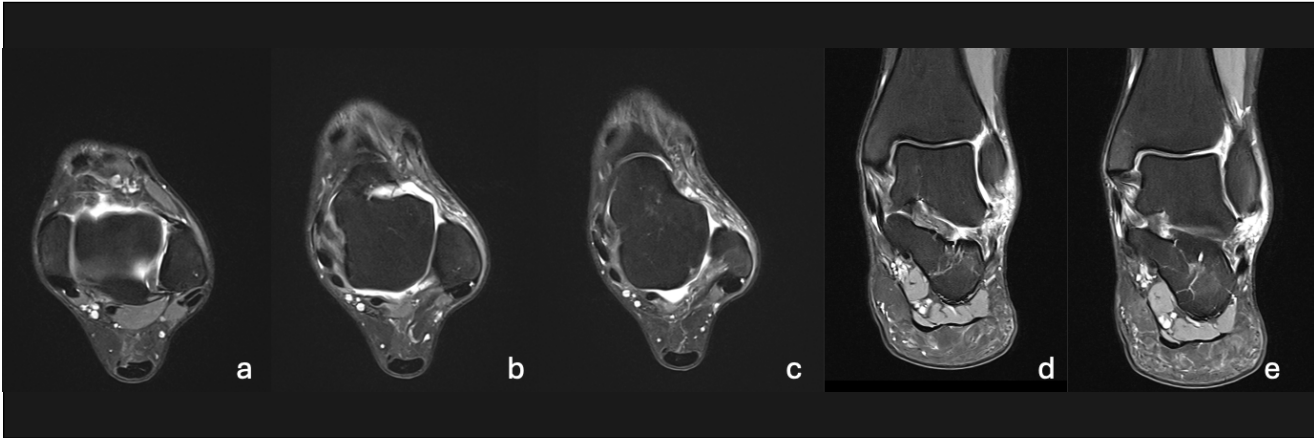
A 33-year-old female patient underwent MRI evaluation 15 days after presentation to the emergency department with an ankle sprain. MRI findings obtained in the subacute phase. Axial (a–c) and coronal (d, e) images show a clearly defined complete rupture of the anterior talofibular ligament (ATFL), with discontinuity and retraction of ligament fibers. Compared to the acute phase, there is a relative decrease in surrounding soft tissue edema, allowing better visualization of ligament morphology. Minimal residual tibiotalar joint effusion is present. The reduced inflammatory background enhances diagnostic interpretability and facilitates more confident grading of ligament injury.
